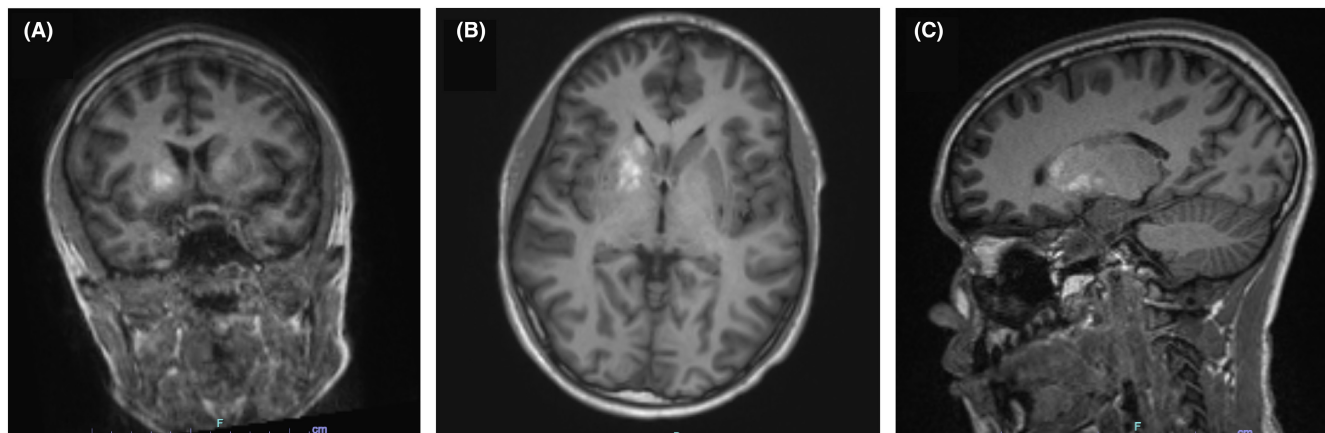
Computed CT scans of the brain showing abnormal hyperintense lesion on the axial (A) and sagittal (B) sections
